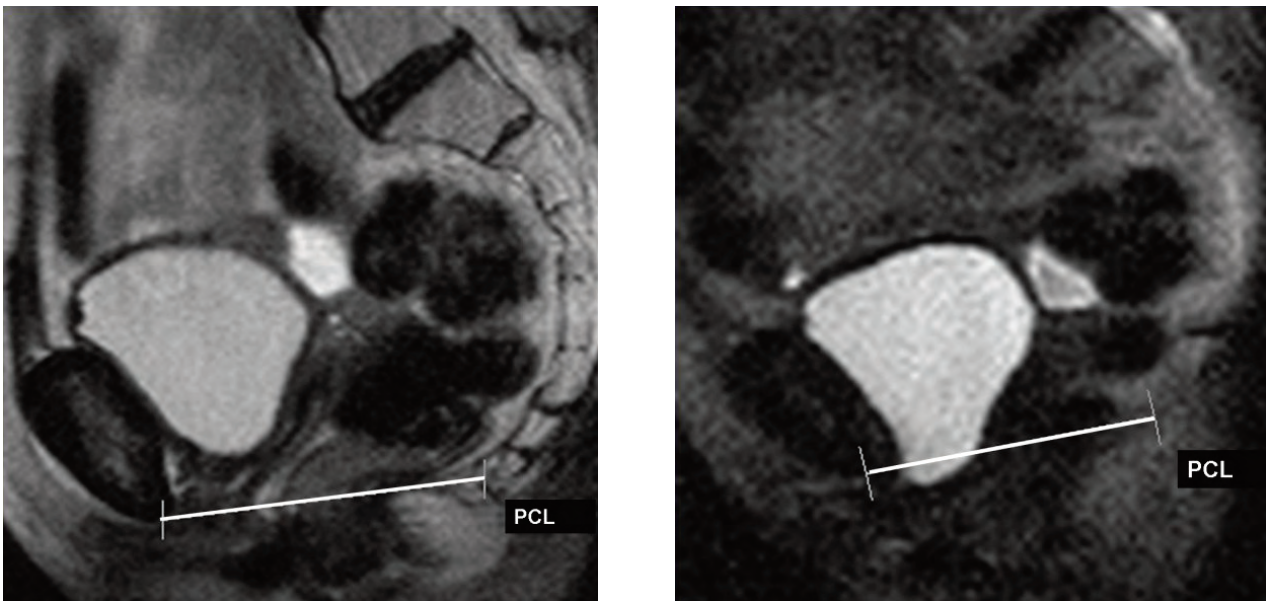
A 50-year-old postoperative severe symptomatic woman (the severity score of incontinence, 10). Sagittal T2-weighted MR image at rest (A) and sagittal modified T2-weighted MR image on maximal straining (B), showing some bladder neck descent. Bladder neck has descended below pubococcygeal line (PCL: pubococcygeal line).
